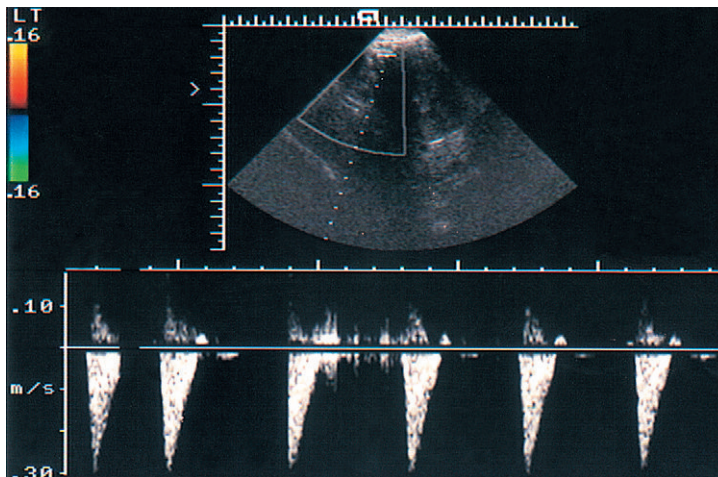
Doppler spectrum of uterine artery blood flow in the postmenopausal uterus.
